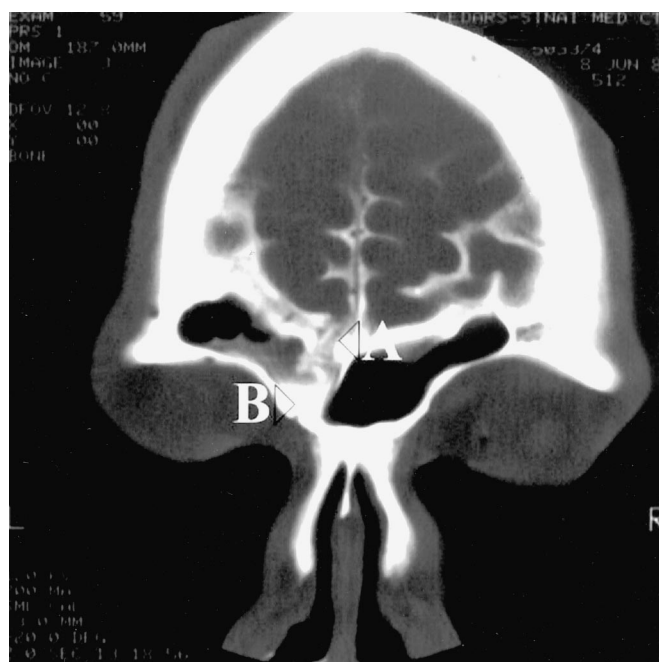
Metrizamide CT cisternogram localizing CSF leak (A) to left frontal sinus in a patient who was stabbed in the left orbit. Contrast material is seen in the frontal sinus (B).
